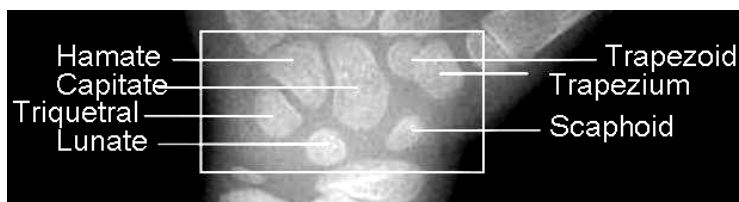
Description of carpal bones in a hand radiograph
